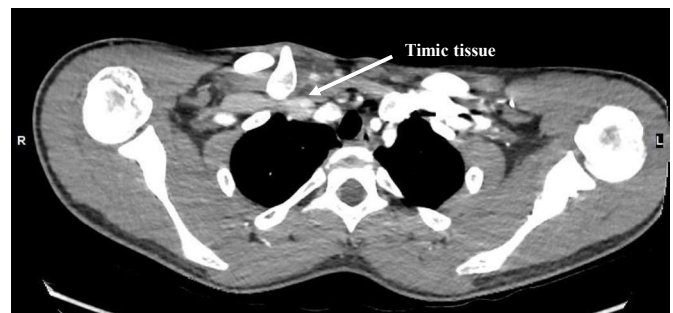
Pre-operative angio-CT scan axial posterior medial clavicle fracture displacement and compression of residual thymic tissue
